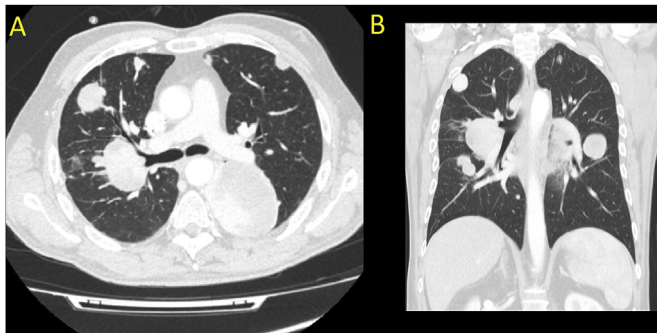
Computerized tomography (CT) scan of the chest during the bleeding episode. Axial (A) and sagittal (B) views shows enlargement of the multiple pulmonary metastases, with invasion of the bronchial lumen by one mass located in the right upper lobe.
